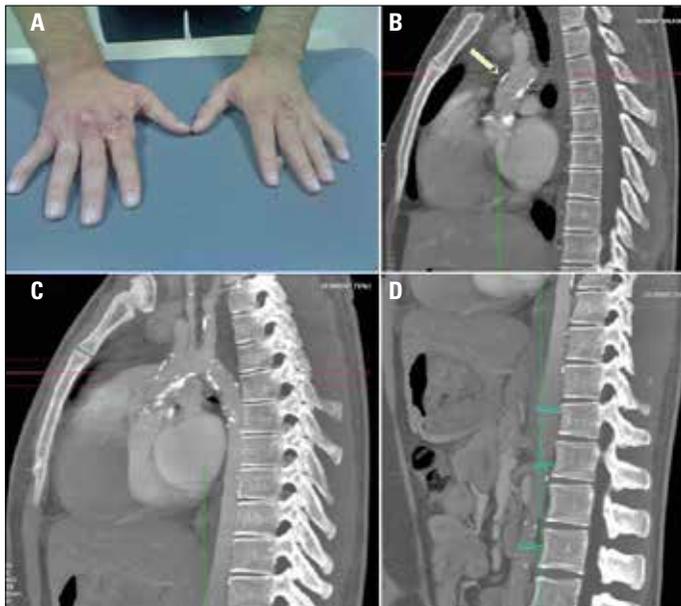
Xanthomas on the back of the his hands (A), computed tomography oblique sagittal images showed diffuse calcium plaques in the thoracic aorta especially in the ascending aorta (B, C), abdominal aorta was 9.6 mm from hiatus to renal artery origin, 13.2 mm distal to this segment and 15.1 mm proximal to this segment (D)
